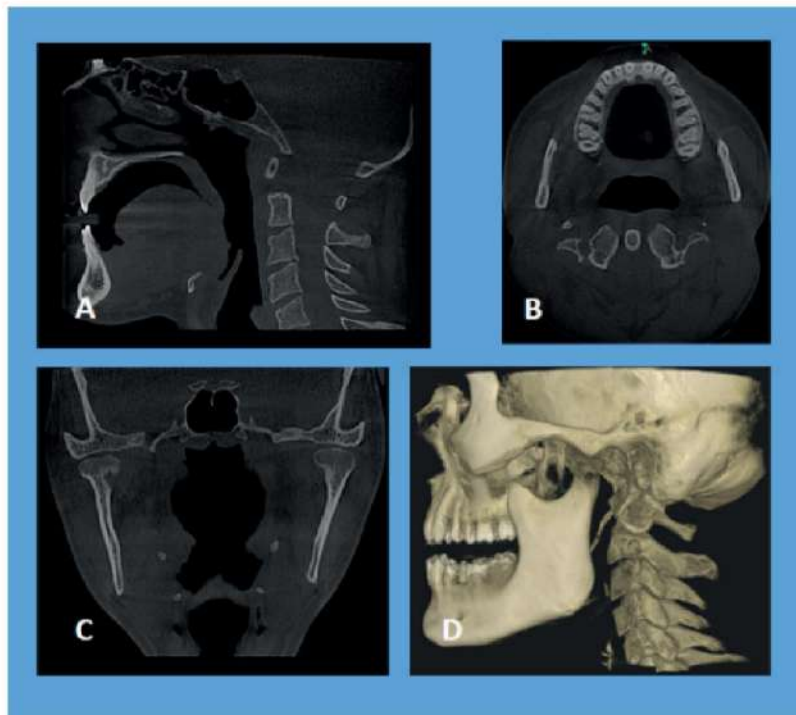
CBCT scans - Extended FOV for Orthodontic and Airway analysis.
